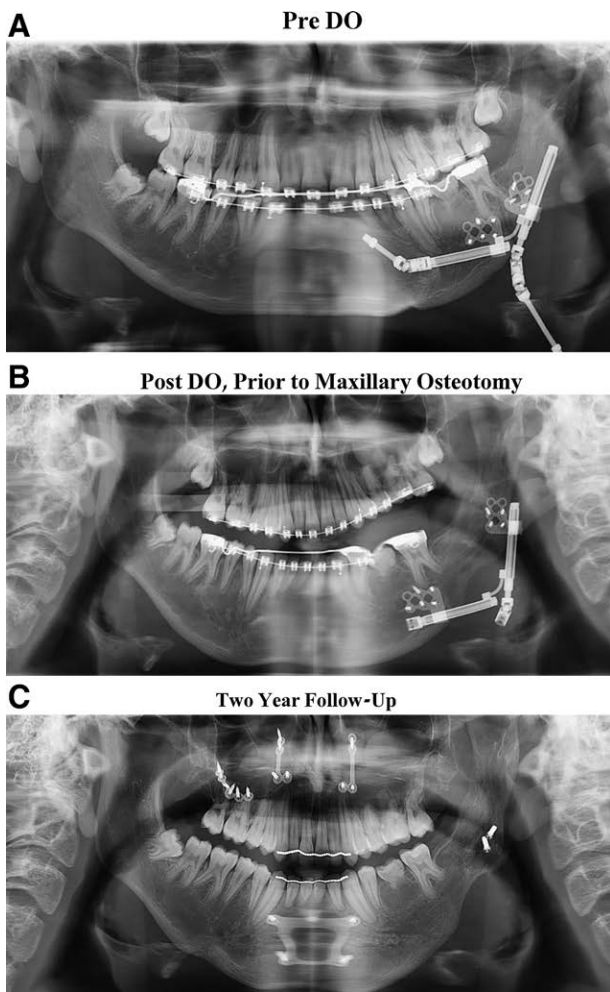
Radiographic surveillance. Pre DO (A), postmandibular DO (B), and final (C) panoramic radiographs of the patient described in Figure 5.
